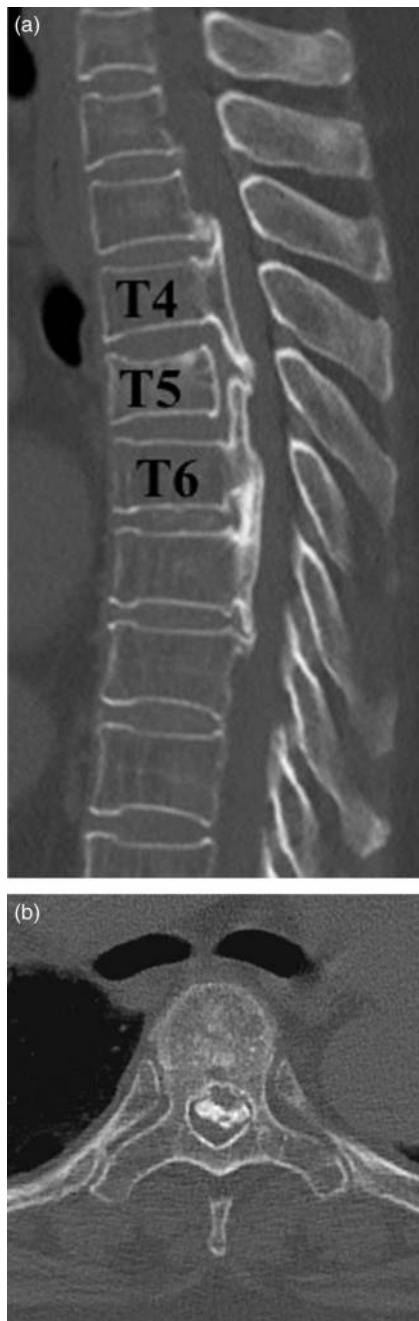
A Sagittal slice, computed tomography (CT) scan of the thoracic spine. Ossification of longitudinal ligament (OPLL) is observed in T3 to T8 level. B Axial slice, CT scan of the thoracic spine showing OPLL.
